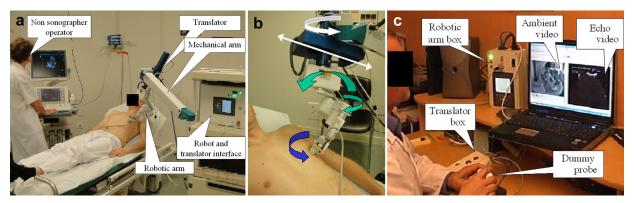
(a) Patient room with the motorized probe holder on the patient, the ultrasound system and non-sonographer operator. The cardiac probe is attached to the robotic arm (tilt, rotation and spin movements), which is fixed to the translational plate to translate the probe within an 8-cm-diameter circle. This motorized system is fixed to an inclinable mechanical arm (ITD, Munich, Germany). The mechanical arm is fixed to a stable cart that can be moved around the bed on the floor. On the cart, the electronic interface box is connected to the Internet for receiving commands sent by the expert sonographer. (b) Proximal view of the robotic arm and translation platform. The white structure to which the probe is fixed is the robotic arm, which allows for changes in orientation within a 45° cone. The blue part (top) is the translation. Translation is operated along the diameter of the disk, which is rotated to select the direction along which the translation will be performed. (c) View of the expert center with the dummy probe for adjusting the orientation of the probe and an electronic box with two push-buttons for translating the probe. Using video, the expert can monitor both the location of the probe and the ultrasound image.
